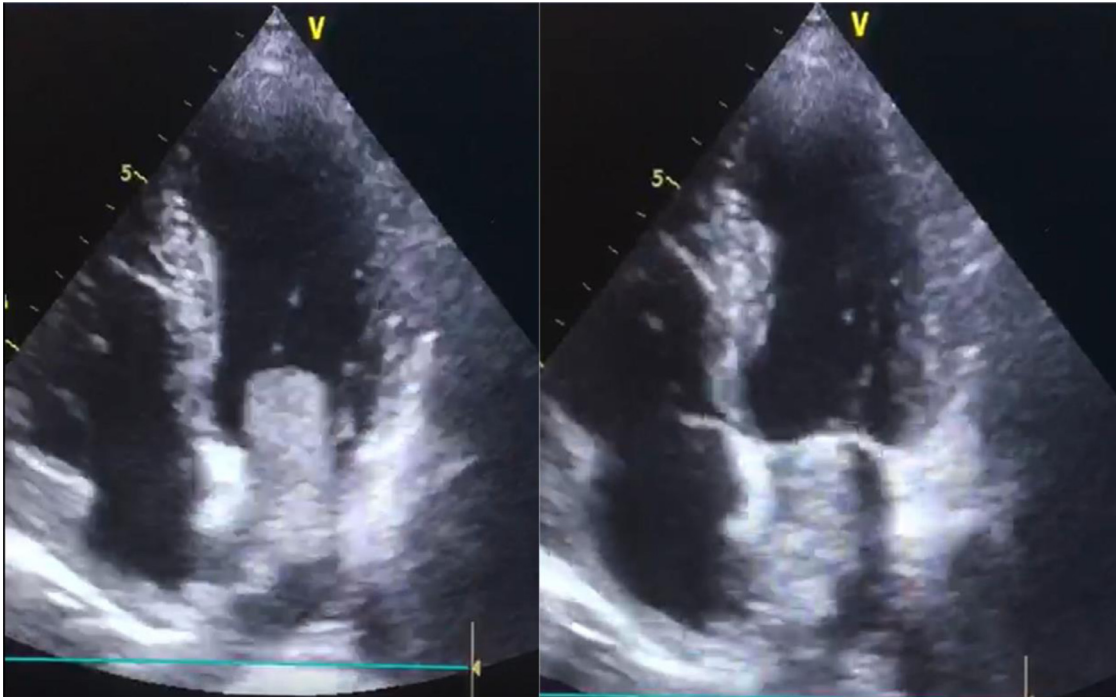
Transthoracic echocardiography during hospitalization showing a large, mobile, lobulated, heterogeneous echoic mass, attaching to the interatrial septal and prolapsing through the mitral valve in diastole, along with the reduction of wall motion in the apical region.
